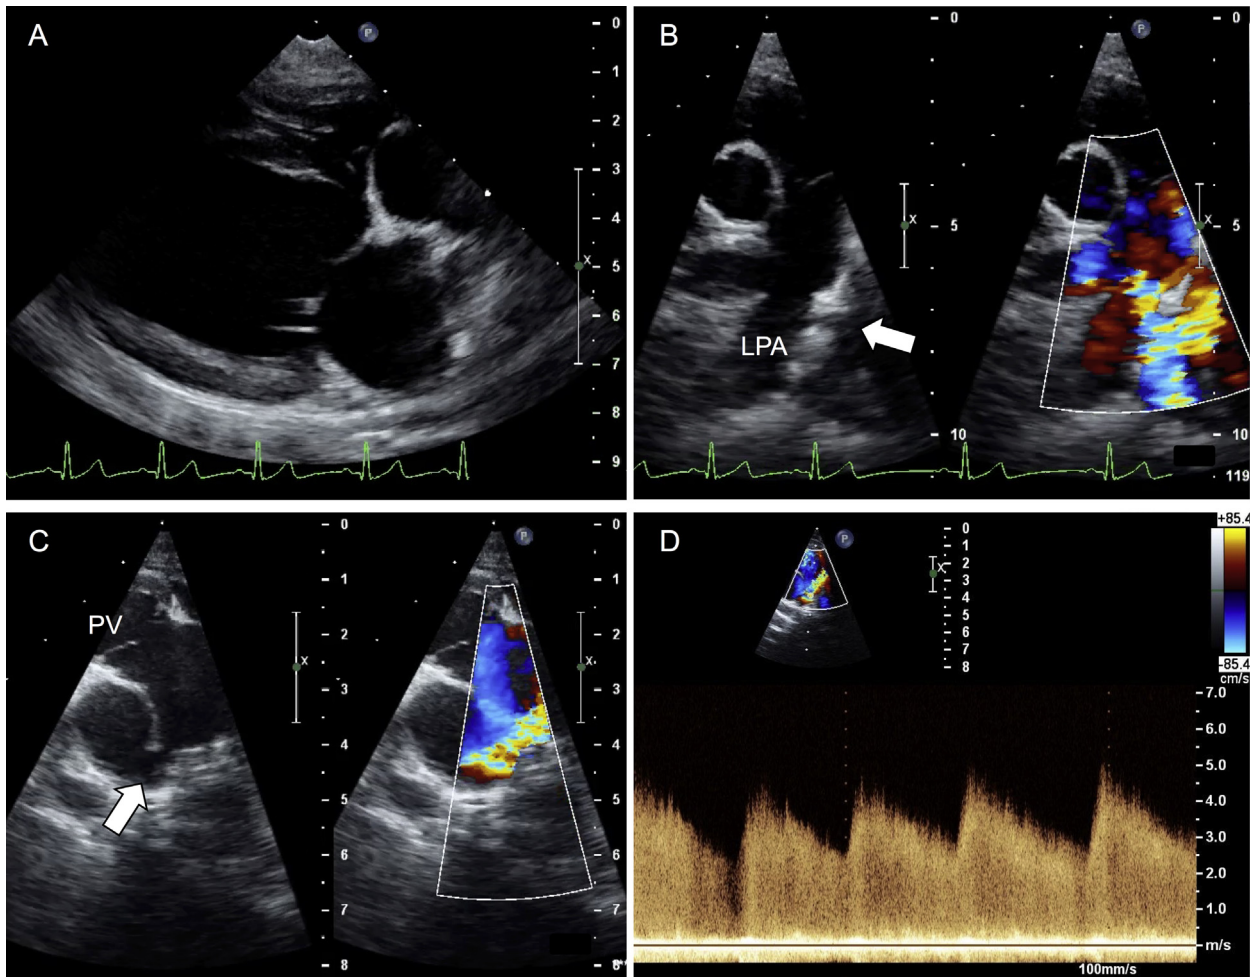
Transthoracic two-dimensional echocardiographic images. (A) Right parasternal long-axis four-chamber view. There is evidence of left ventricular and left atrial enlargement. (B) Right parasternal short-axis basilar view with color Doppler comparison. Note the atypical, almost perpendicular connecting angle of the continuously shunting vessel (*white arrow*) near the junction between the main and branch pulmonary arteries. (C) Left parasternal short-axis basilar view with color Doppler comparison. The same continuously shunting vessel (*white arrow*) appears to inset near the origin of the right pulmonary artery. (D) Continuous-wave Doppler indicating continuous left-to-right flow with an average peak velocity of 4.4 m/sec. LPA, Left pulmonary artery; PV, pulmonic valve.
